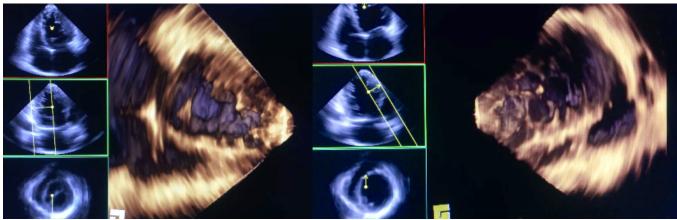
Two-chamber view in 3D echocardiography showing prominent trabeculae and deep intertrabecular recesses.
